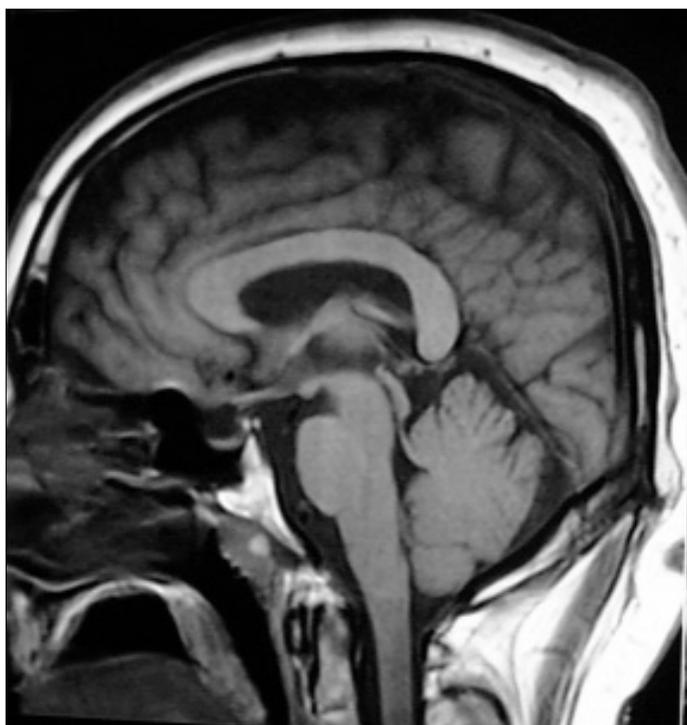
Sagittal T1-weighted image demonstrating atrophy in the cerebellar vermis.
